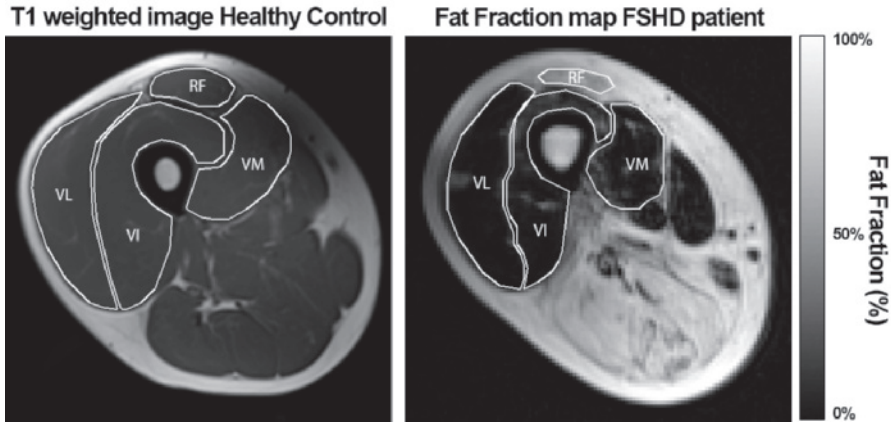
Left: T1-weighted MR image of the thigh muscles of a healthy volunteer. Right: fat fraction map of the thigh muscles of an FSHD patient acquired by a 2 pt Dixon method. Regions of interest are drawn around the *m. rectus femoris* (RF), *m. vastus lateralis* (VL), *m. vastus intermedius* (VI) and *m. vastus medialis* (VM).
